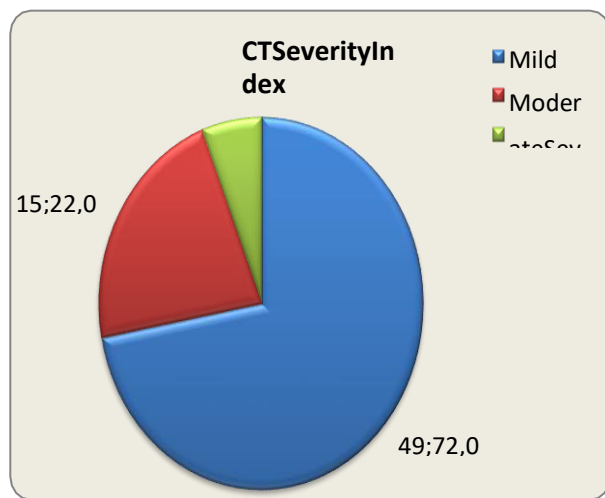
Balthazar CT severity index in patients with AP
